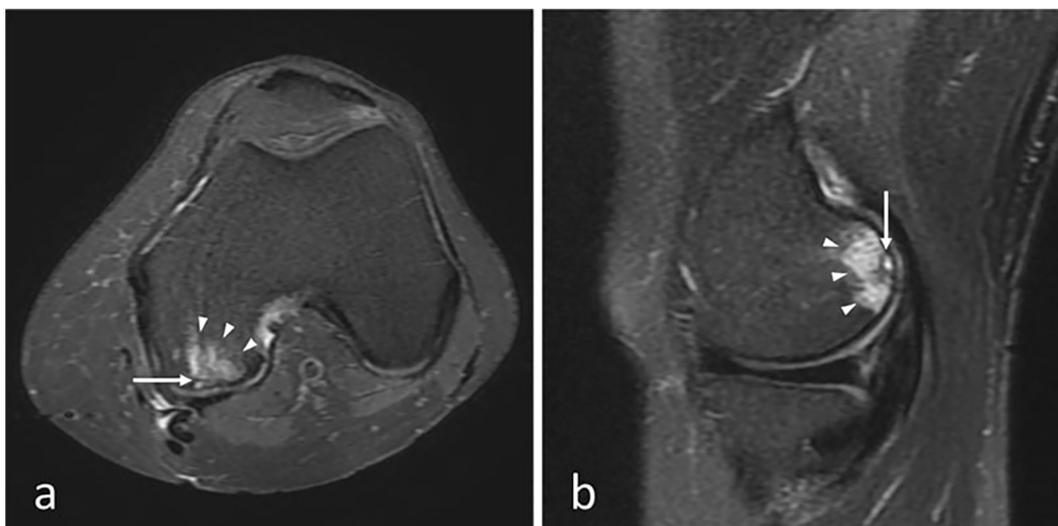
Axial (a) and sagittal (b) views of proton density MRI with fat saturation showing subchondral insufficiency fracture (arrow) with marrow edema (arrow heads) in posterior non-weight-bearing zone of the medial femoral condyle in a 62-year-old female.
